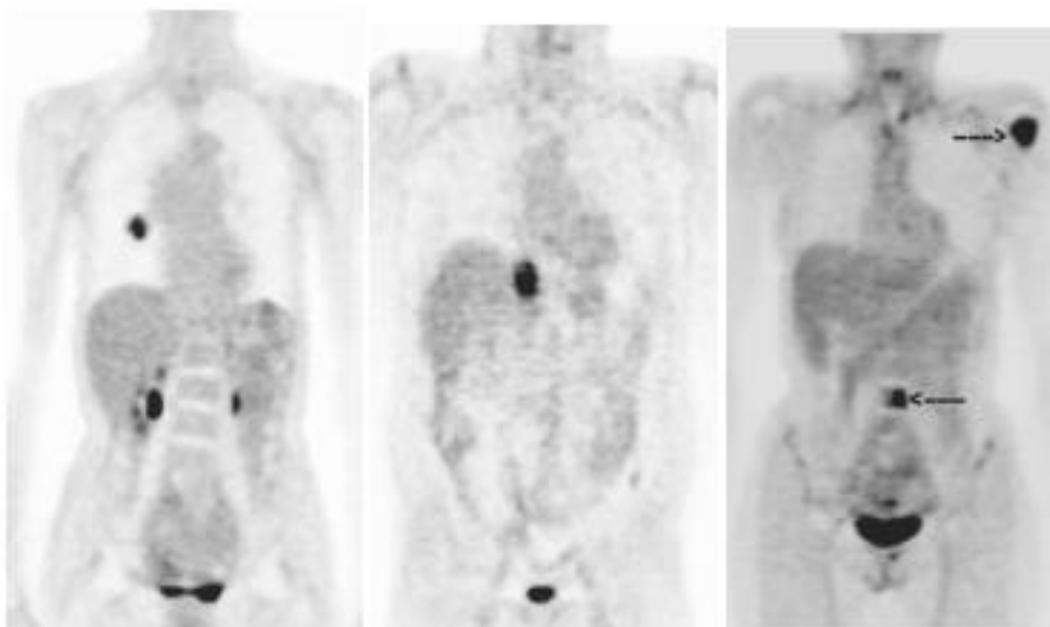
FDG-PET whole-body scans coronal slices in a patient with multiple bone lesions in shoulder and lumbar-spine (arrows), liver, and lung.
